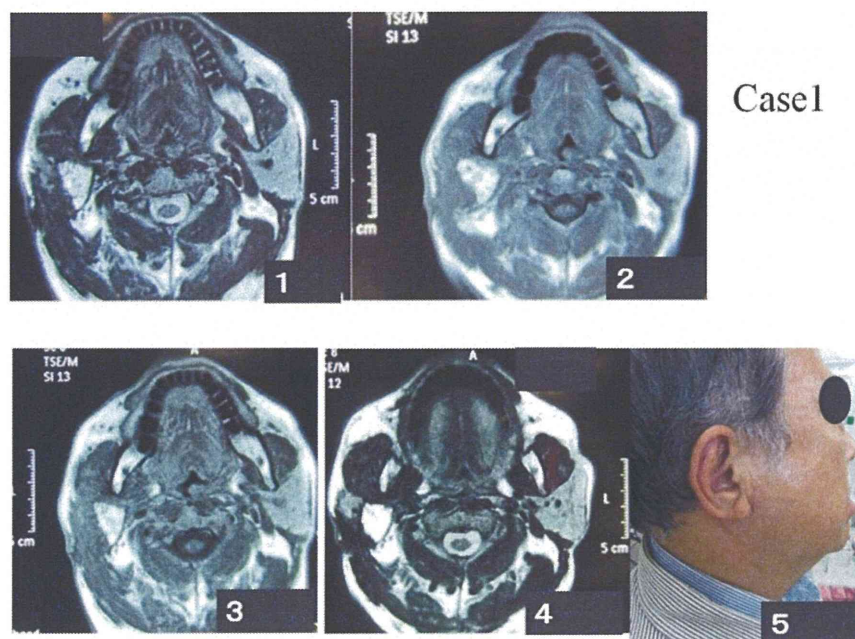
The change of grafted fat volume through MRI in recurrent parotid cancer. Case 1: recurrent parotid cancer. MRI (postoperative 1 month to 12 months) 1: postoperative 1 month, 2: postoperative 3 month, 3: postoperative 6 month, 4: postoperative 12 month, 5: patient's profile in postoperative 12 months.
